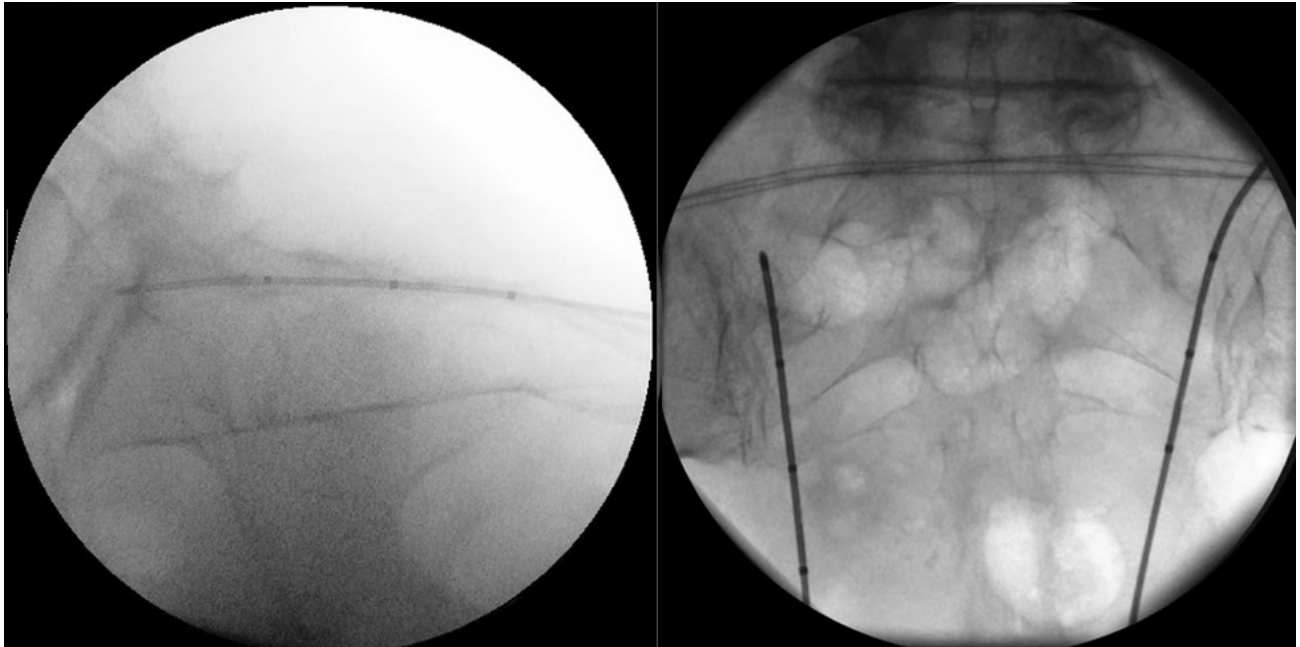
Representative lateral and anterior-posterior X-ray images after final positioning of the multi-electrode probe. (With permission from Bayerl et al., 2020)
